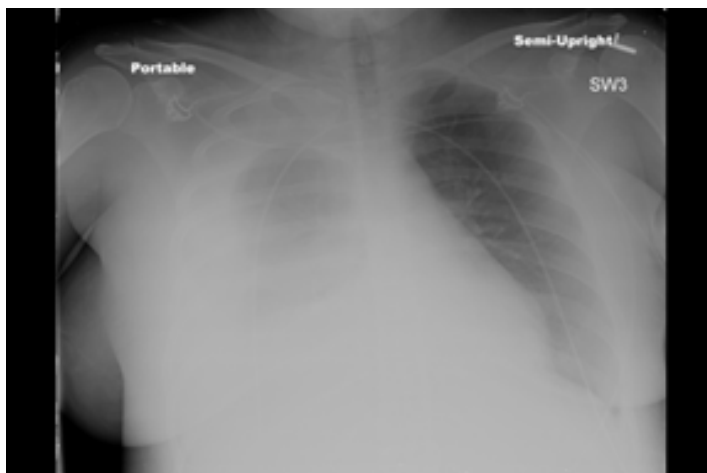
Portable semi-upright chest radiograph showing large right pleural effusion.
